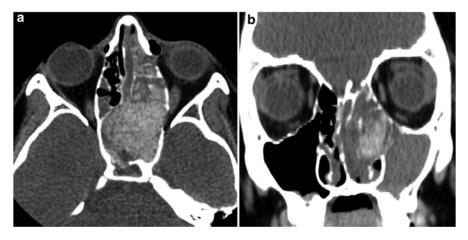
Allergic fungal sinusitis. (a) Non-contrast axial and (b) coronal CT images show complete opacification of the sphenoid, left ethmoid and maxillary sinuses with expansion of the left ethmoid and sphenoid sinuses. Additionally, there are multifocal hyperattenuation within the opacified sinuses and polypoid soft tissue opacification within the left nasal cavity. On axial view, there is rarefaction and dehiscence of the bony septations and the walls of the sphenoid and ethmoid sinuses
